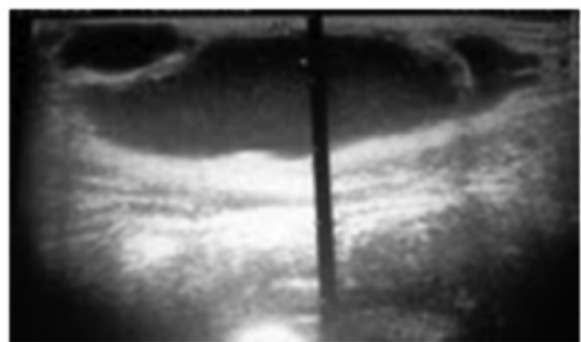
Ultrasonographic image of the subcutaneous cystic lesion which is septated into 3 isolated compartments, containing echogenic material.
